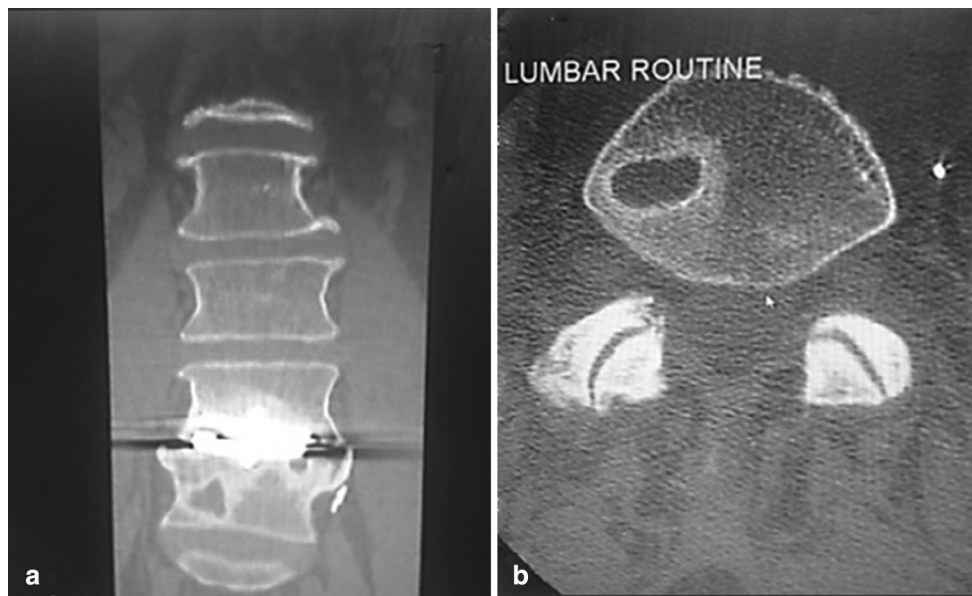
Sagittal (a) and axial (b) CT scans from case 2 showing L4 subsidence on the right side of the vertebra and one large osteolytic cyst in L5. Smaller osteolytic formations are also evident at superior L5
